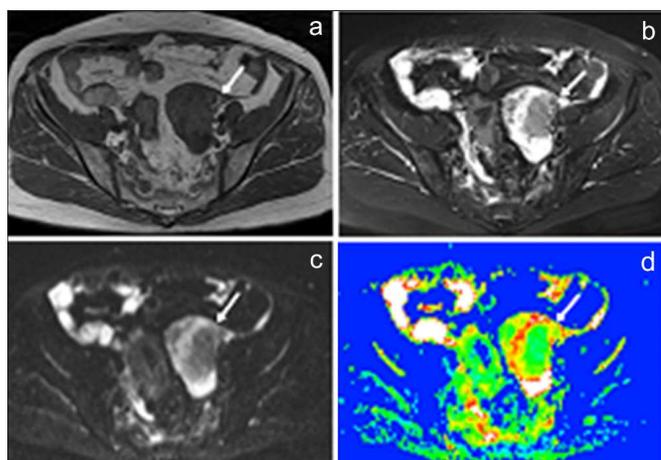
(a - d) Typical case 2: A female patient, 52 years old, ovarian metastatic carcinoma. (a) Solid and cystic masses in the right appendage area, with low signals (arrows) on the T1WI. (b) The T2WI fat suppression sequence showed solid and cystic lesions. (c) Solid lesions on the DWI were high signals. Cystic lesions on the DWI were equal signals and high mixed signals. (d) The ADC of solid lesions in the ROI was approximately $(1.39 \pm 0.21) \times 10^{-3} \text{ mm}^2/\text{s}$.
